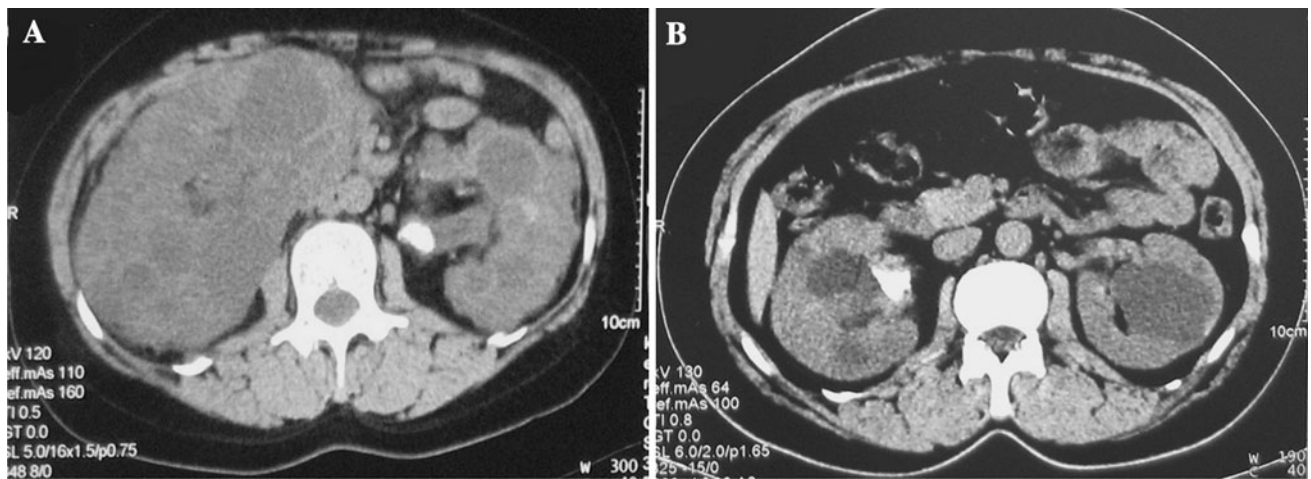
Representative sections of renal calculi on abdominal CT: a 34-year-old male presenting with left flank pain had 15 mm obstructing UPI calculus; b 45-year-old male presenting right flank pain had mid calices calculus
